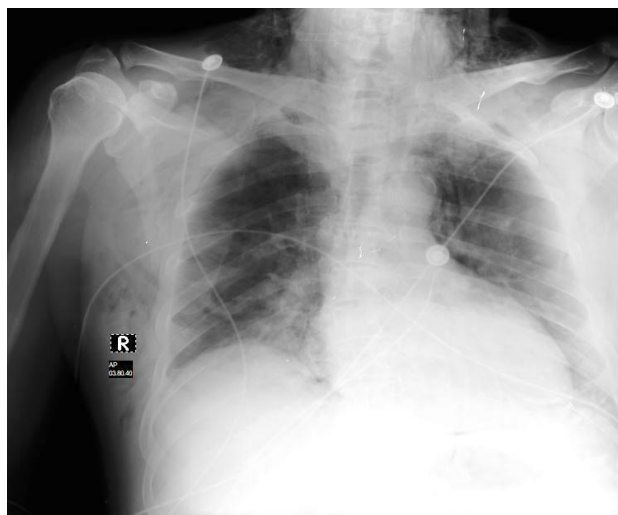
The chest X-ray AP of patient IKS taken on August 28, 2021, demonstrated significant radiographic improvement, characterized by decreased pneumonic infiltrates, accompanied by the presence of subcutaneous emphysema and pneumomediastinum
